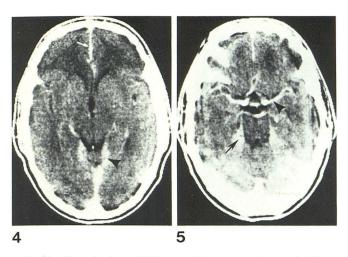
Normal enhanced CT scan. Enhancement of tentorial incisura (arrowhead) and falx (arrow).
